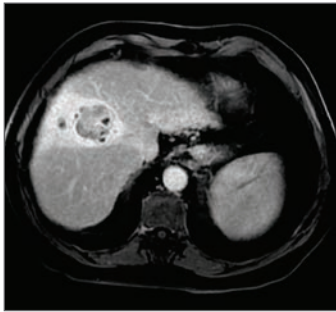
Post radioembolization MRI.
